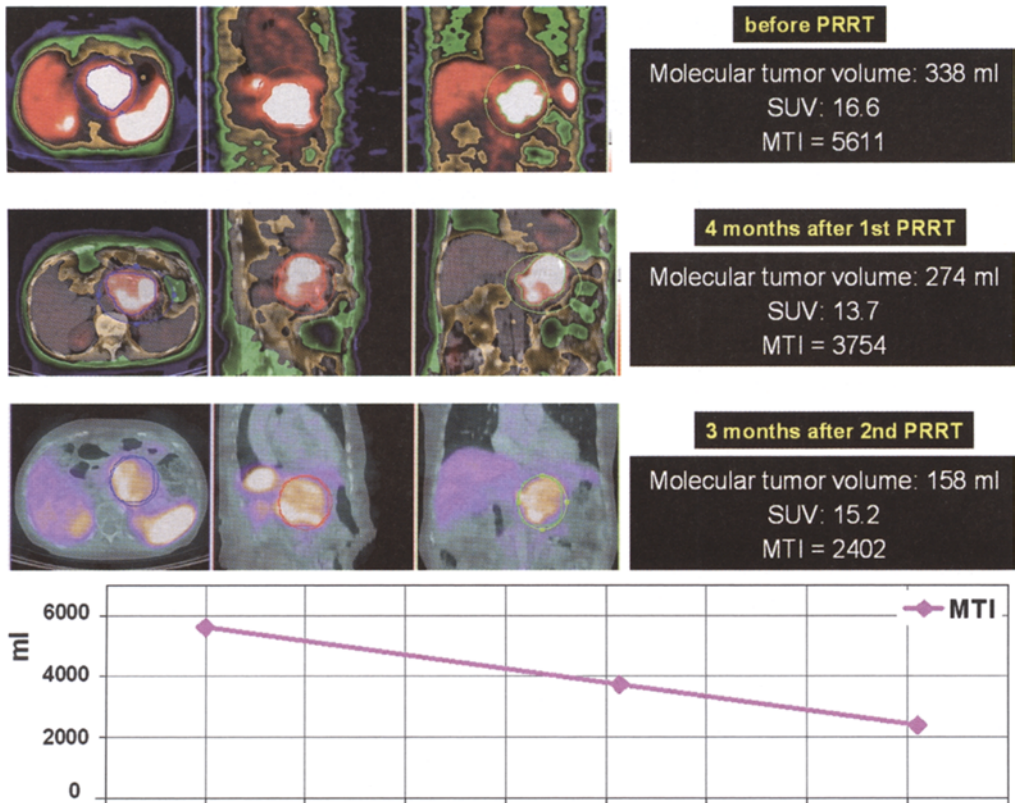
Molecular imaging for measuring response after therapy by calculating the molecular tumor index using ROI technique and Ga-68 DOTA-NOC receptor PET/CT. Metabolic/molecular tumor index (MTI) = molecular tumor volume (MTV) multiplied by SUV. The significant decrease in MTI over time correlated with the improvement of the patient's clinical symptoms
